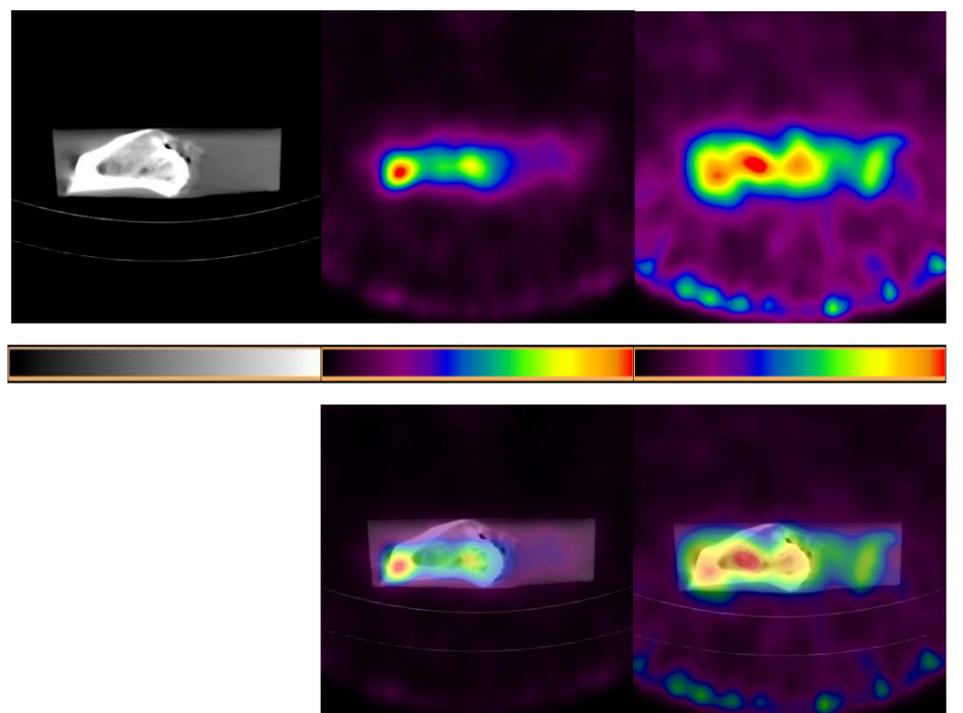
Top row, from left to right: 140 kVp low dose CT, 84 keV 20% width energy window and 269 keV 20% width energy window SPECT reconstructions. Bottom row: the SPECT reconstructions fused with the low dose CT.
